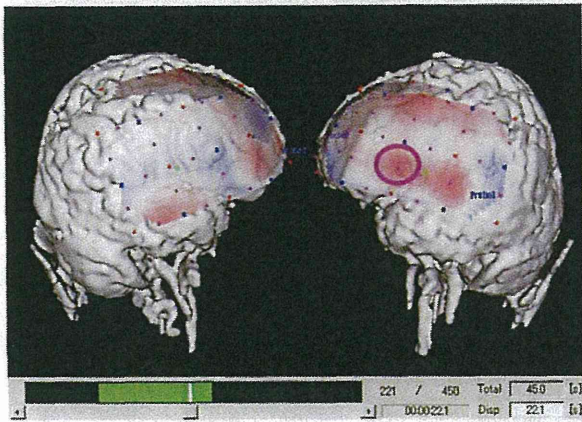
課題遂行中の Oxy-Hb の光トポグラフィーと MRI の合成画像
